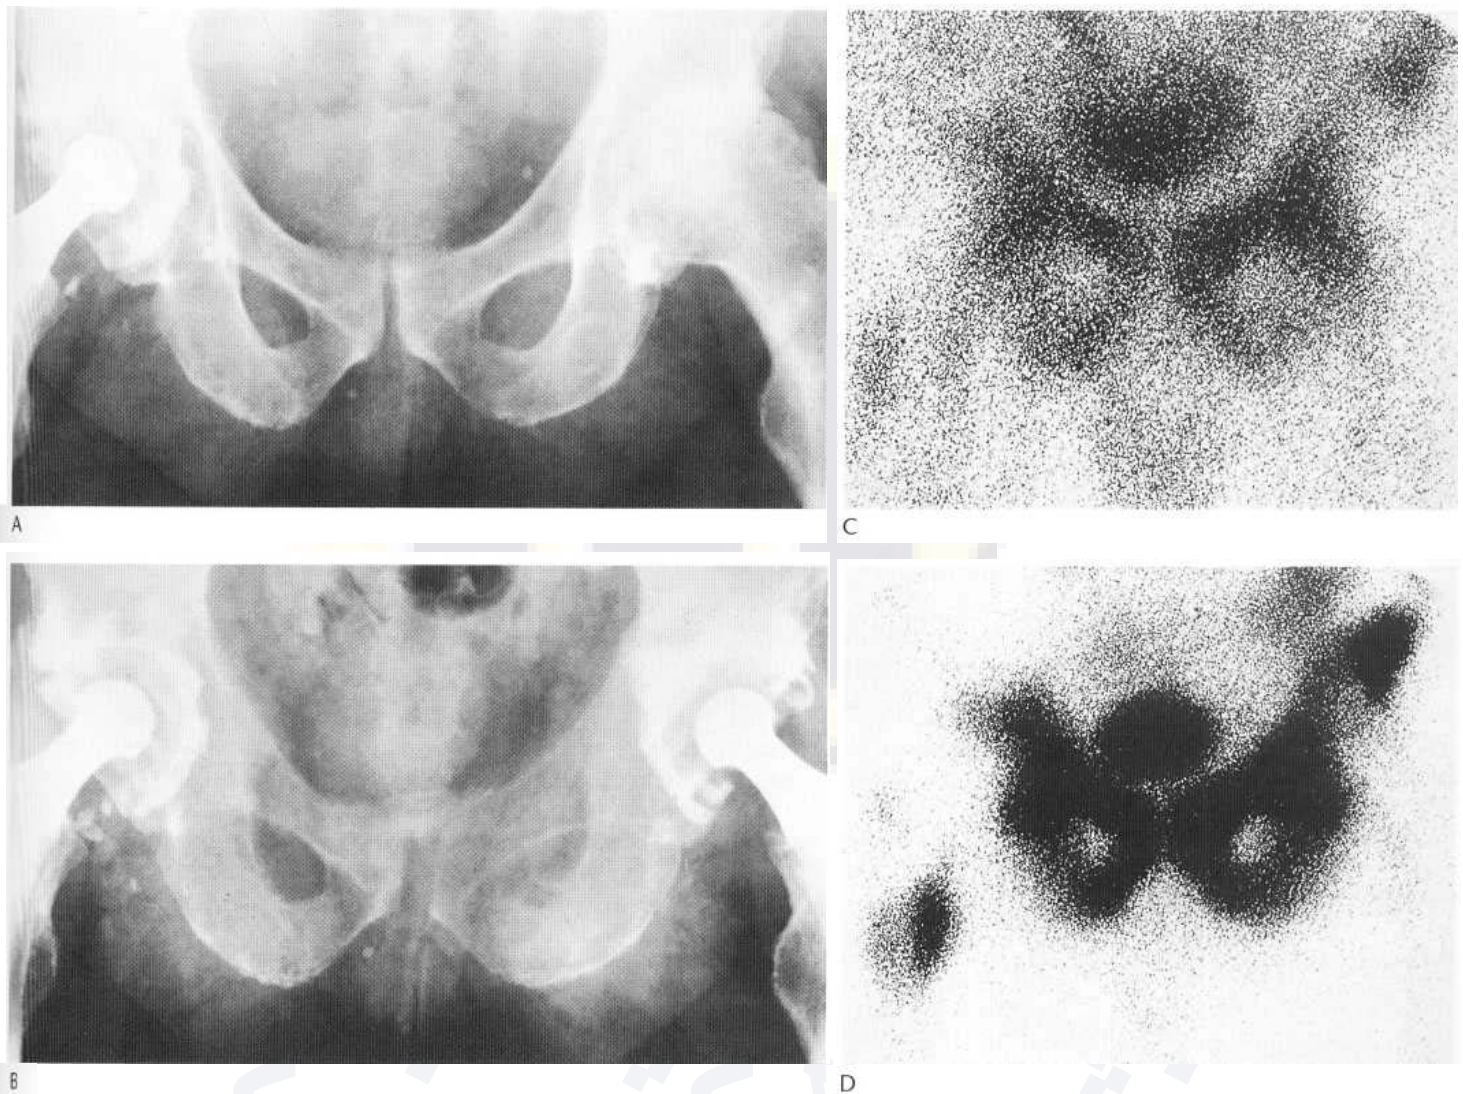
Carcinoma of the prostate with expansile lytic metastasis. (A) A view of the pelvis before the onset of symptoms reveals no abnormality in the pubic rings. (B) Five years later the patient was complaining of severe pain in the groin. Note the ill-defined trabecular pattern, expansion of bone and ill definition of cortex that has developed since the previous examination. (C) Blood-pool phase of a bone scan and (D) delayed image reveals a marked increase in activity. Note the abnormality in the lesser trochanter of the right femur. These features could not be distinguished from active aggressive Paget's disease on purely scintigraphic grounds except that the lesion in the right femur has not started at a joint. The diagnosis was established by biopsy and the presence of a very high acid phosphatase level in the blood.
